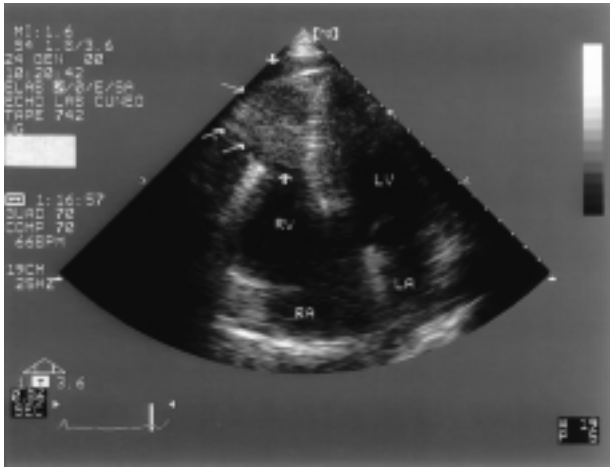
Two-dimensional transthoracic echocardiographic study, 4-chamber view. A single, non-mobile echogenic mass in the apical portion of the right ventricle (RV) is apparent (arrows). LA = left atrium; LV = left ventricle; RA = right atrium.
